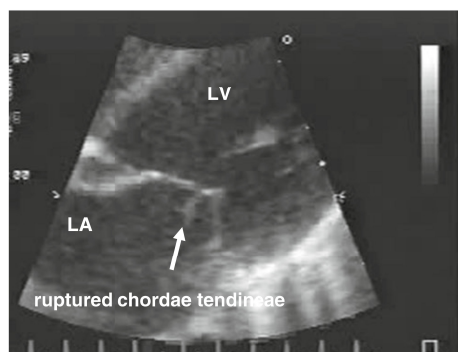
Preoperative transthoracic echocardiogram from patient 9. This patient had respiratory distress and perfusion failure at the first visit and had been intubated at the previous hospital; the patient was transferred to our institution the same day. Posterior ruptured chorda was detected (arrow)
